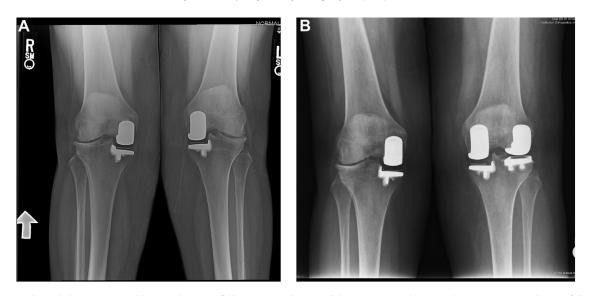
(A) This AP radiograph shows a 63-year-old man with a successful lateral UKA and now medial compartment arthritis. (B) The patient was treated successfully with a medial UKA for the disease progression in the medial compartment. AP, anteroposterior; UKA, unicompartmental knee arthroplasty.
